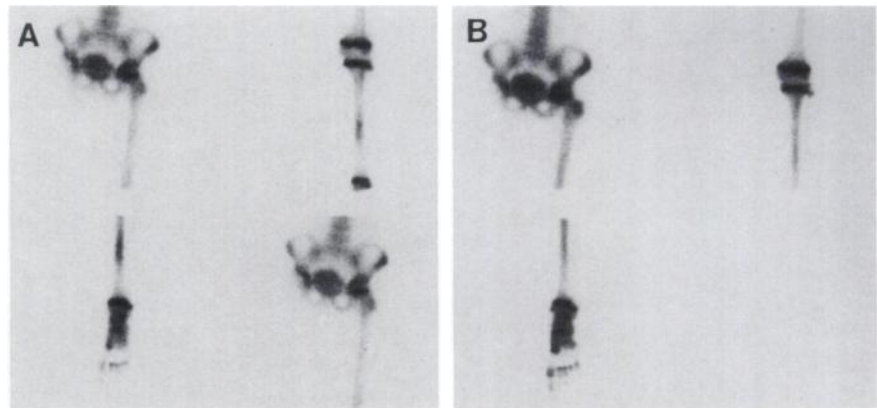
A 9-yr-old girl with osteosarcoma of the distal right femur. The patient underwent hip disarticulation and chemotherapy. Seven months after surgery, bone scintigraphy shows spindle-shaped abnormal uptake in the middle third of the left tibia (A). The abnormal uptake disappeared 9 mo later without treatment (B).
